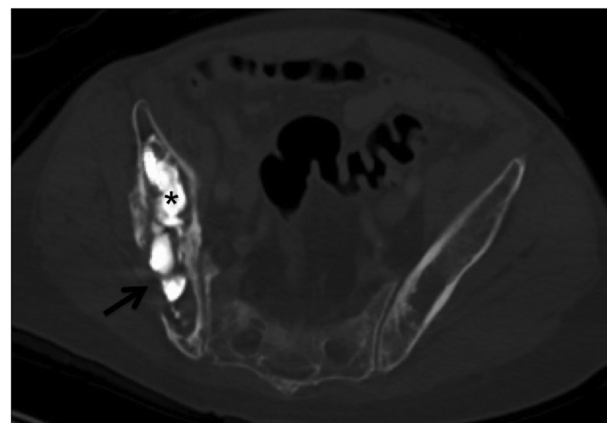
(Patient 2) Axial computed tomography image shows satisfactory bone cement (*) distribution throughout the lytic tumor cavity and one of the many areas of complete cortical erosion (arrow) without capsular leakage of cement.
